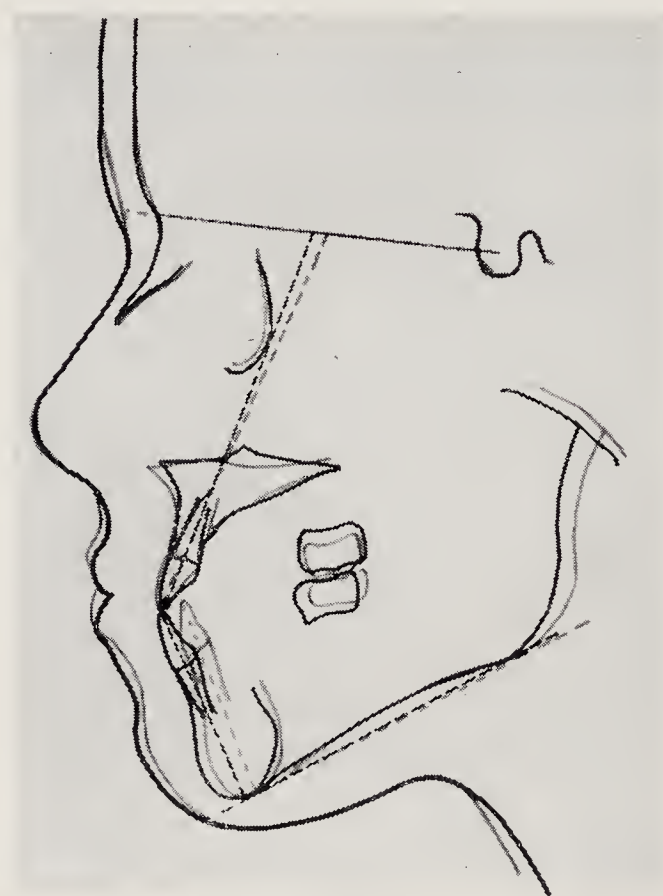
Case 2159. Age $7\frac{9}{12}$. Angle Class III. Treatment with sliding activator from January, 1954 to June, 1954. A, Superimposed tracings of lateral radiographs. B, Models at commencement and on completion of treatment.
